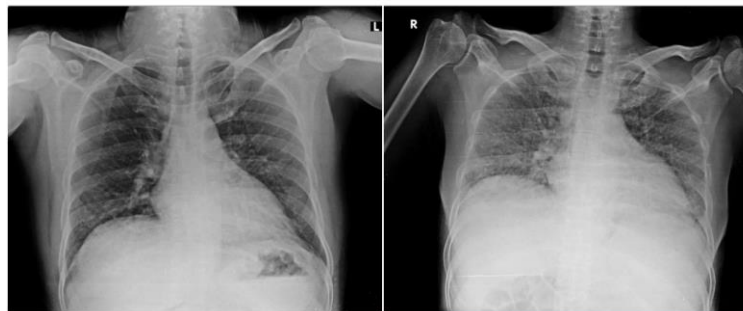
Chest X-ray showing disseminated TB
